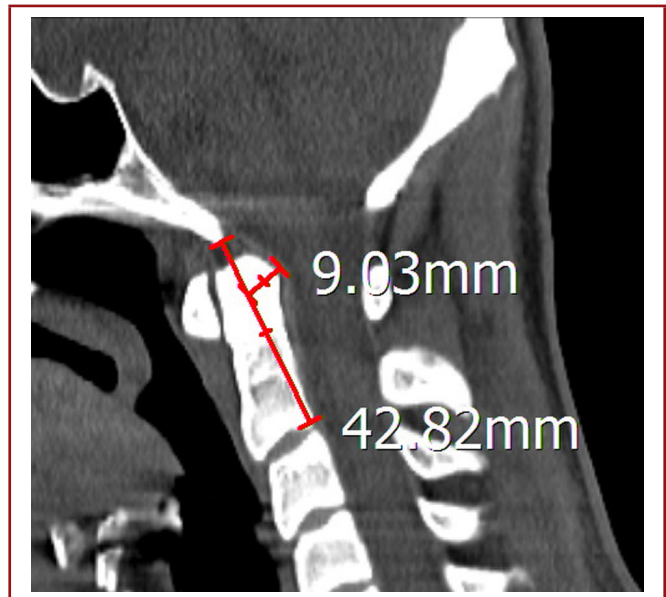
The amount of ventral cervicomedullary encroachment by the odontoid the measurement proposed by Grabb-Oakes measured in a sagittal CT image as the distance to a perpendicular line traced from the most posterior region of the dura mater covering the dens to the line that goes from the inferior surface of the basion to the posterior inferior aspect of the C-2 vertebral body.
